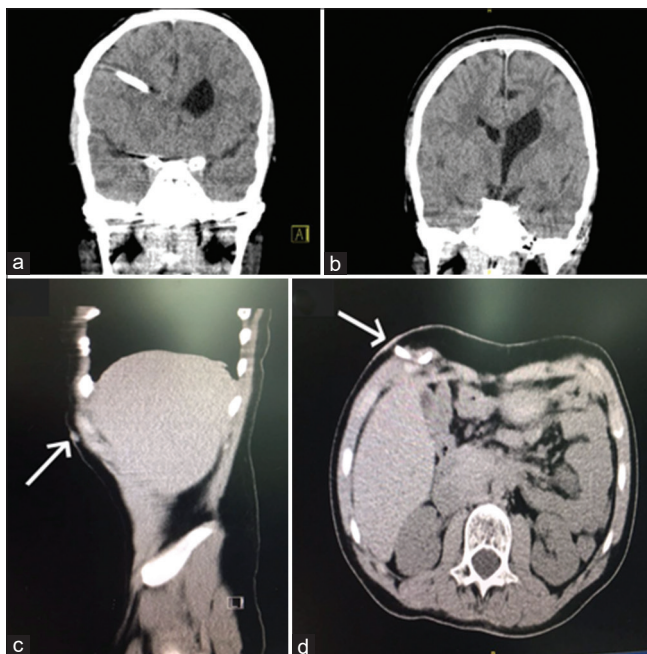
(a) Preoperative coronal head computed tomography showing the proximal end of ventriculoperitoneal-shunt placed in the right lateral ventricle. (b) Postoperative coronal head computed tomography after removing of the ventriculoperitoneal shunt. (c and d) Preoperative sagittal and transversal abdominal computed tomography showing the distal tip of ventriculoperitoneal shunt protruding through the right anterior abdominal wall
